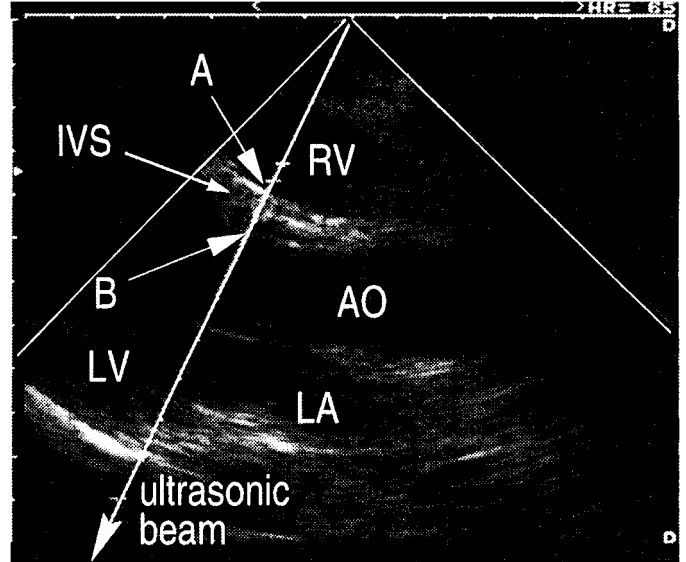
A standard B-mode longitudinal-axis image showing the cross-sectional area around the detected points preset in the IVS of a presumably healthy 39-year-old male volunteer. Points A and B are on the RV and LV of the IVS, respectively. The ultrasonic beam passing through the two points is almost perpendicular to the IVS during the measurements.
